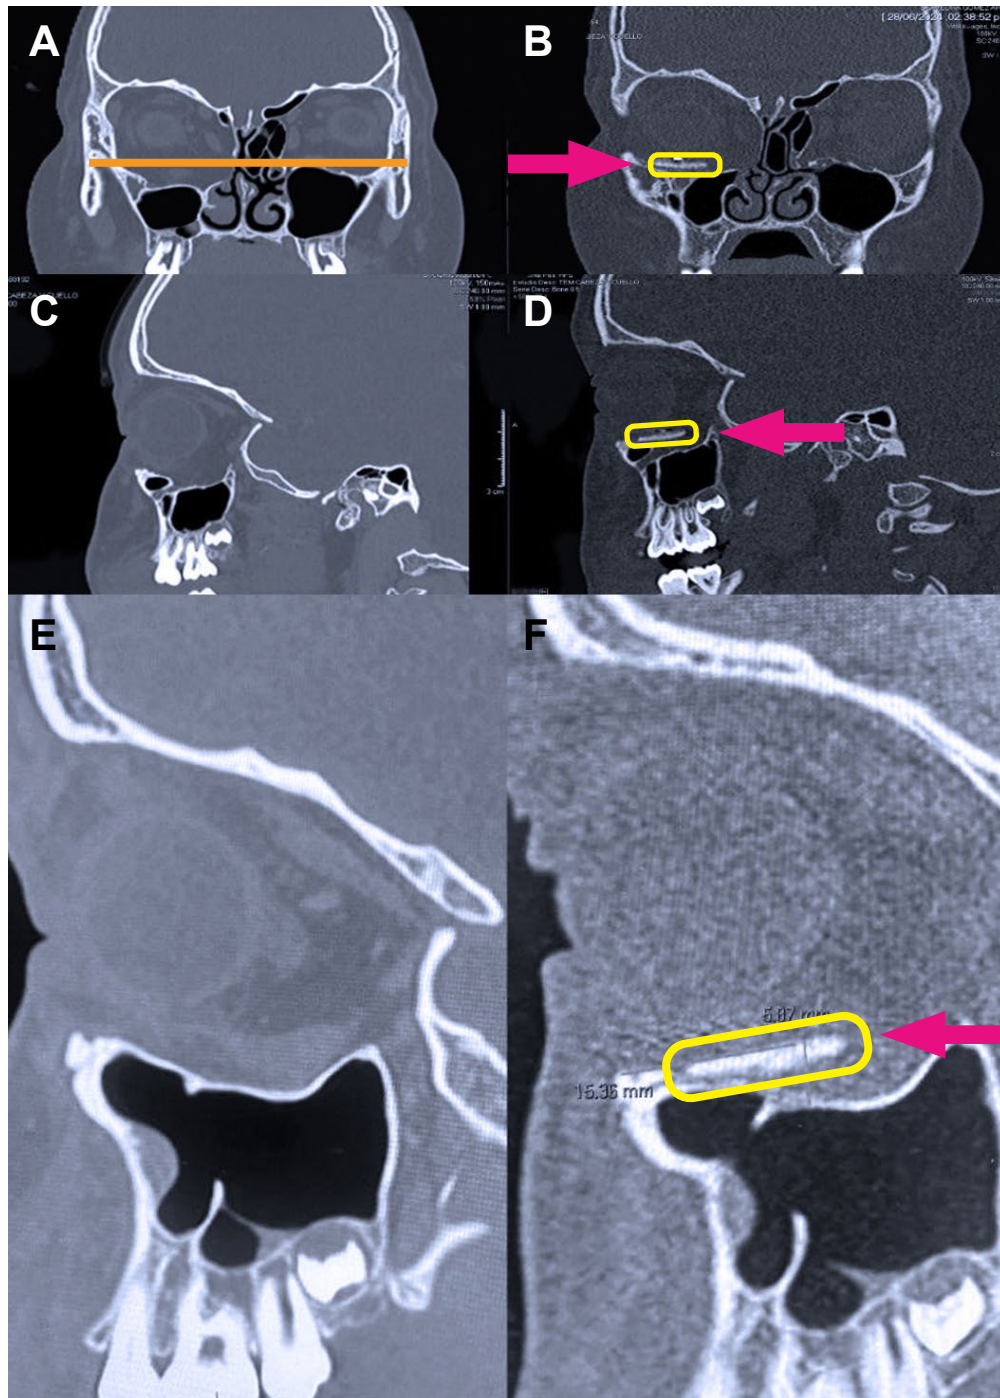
Computed tomography of the orbits in coronal (A, B) and sagittal (C–F) sections
